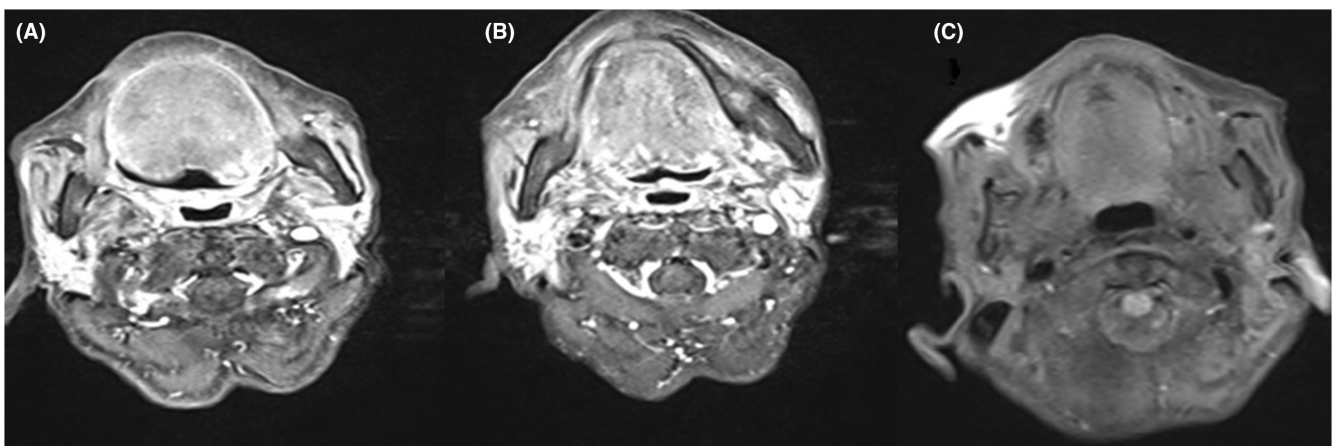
Post-treatment MRI (19 months after completion of chemoradiotherapy) showing dramatic response to treatment. (A and B) T1-weighted sequence with gadolinium contrast. (C) T2-weighted sequence showing complete clinical response.
